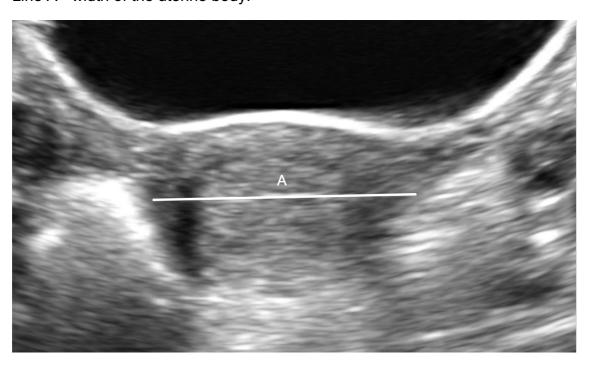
A transverse transabdominal ultrasound image of the uterus showing landmark points for measurement
